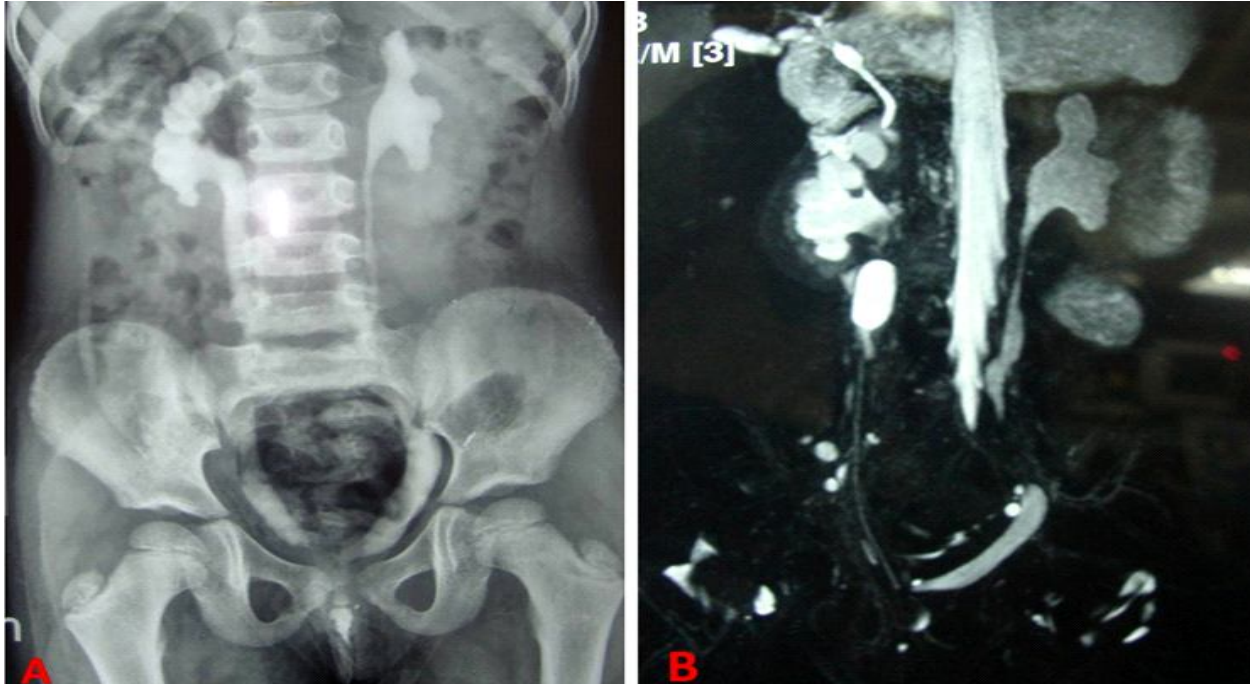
Intravenous urography (IVU) film showing bilateral mild to moderate hydronephrosis with bilateral ectopic ureters. Fig. 2B: Magnetic resonance imaging (MRI) film showing bilateral ureters opening into the vagina
